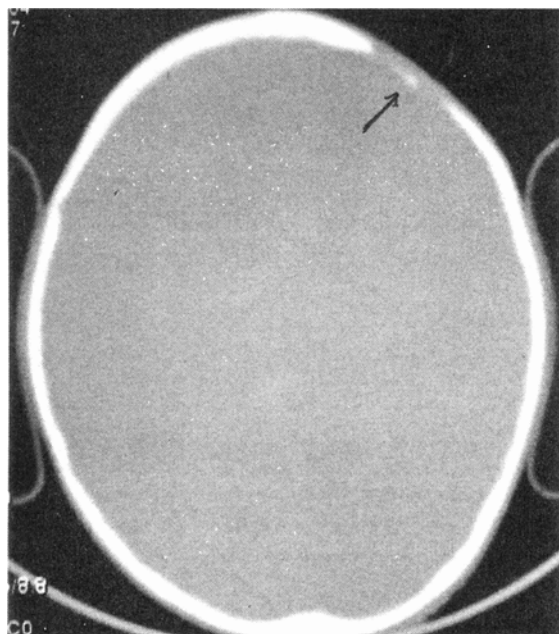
Axial CT scan of the head (bone window setting) shows a lytic lesion with sharp margins involving both tables of left frontal bone. A small bony speck (button sequestrum) is seen in the center of the lesion.
